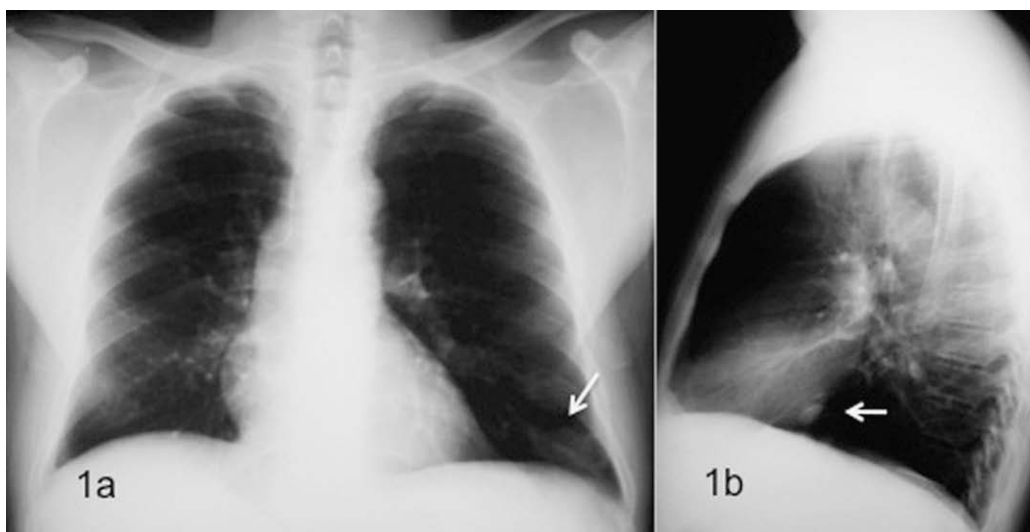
Posteroanterior (a) and lateral (b) chest radiographs, where a nodule (white arrows) can be seen in the left lower lobe.
